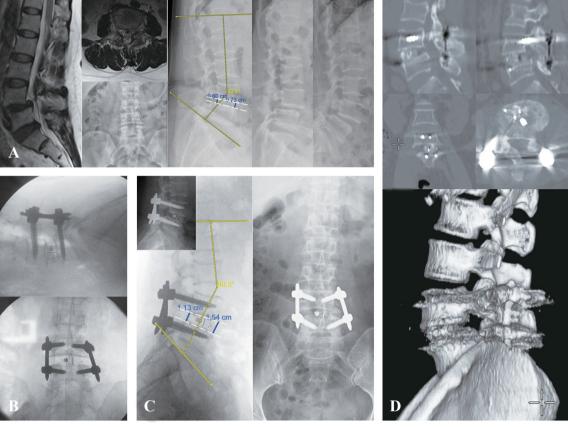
(A) Preoperative magnetic resonance imaging and X-ray images of a male patient with spondylolisthesis due to isthmic at the L4-5 level. (B) Intraoperative fluoroscopic image. (C) Postoperative X-ray at 3 months showing restoration of disc height and reduction of spondylolisthesis. (D) Postoperative lumbar spine computed tomography images at 6 months demonstrating the formation of bridging bone both intra-cage and extra-cage.
